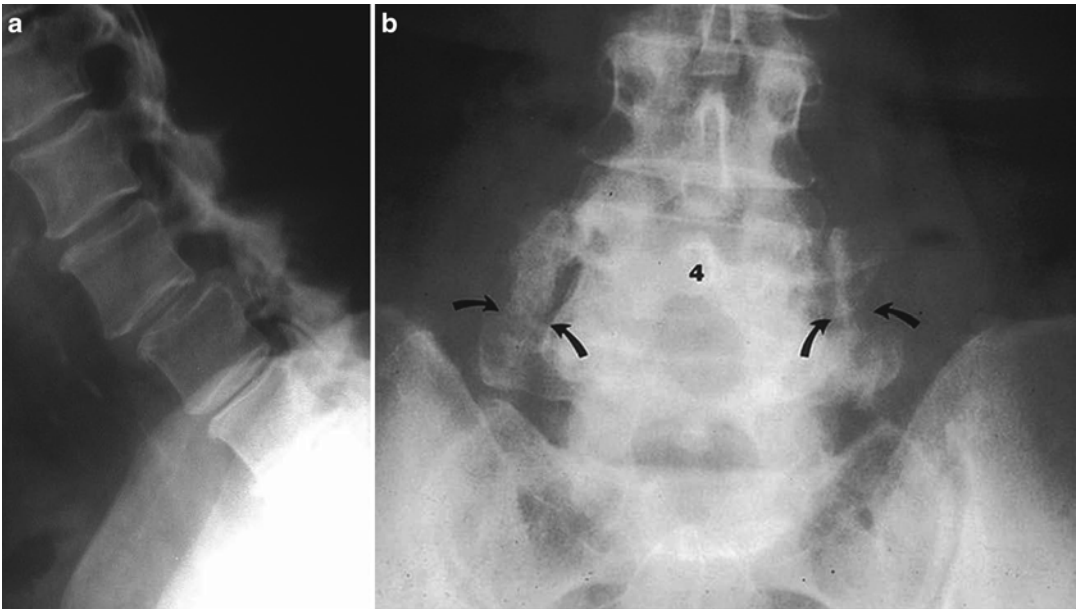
(a) Representative lateral radiograph of degenerative spondylolisthesis; (b) AP radiograph of a noninstrumented posterolateral fusion. *Arrows* demonstrate a
